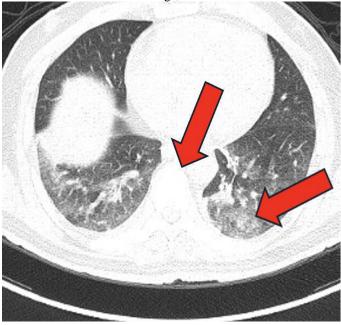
CT Thorax showing newly developed incomplete consolidation in both lower lung lobes dorso-basally.
